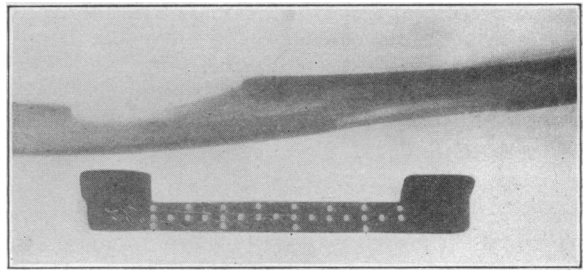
Lateral roentgenogram four months after lengthening of the femur in a case of infantile paralysis. A gain of two and one-half inches was secured.
